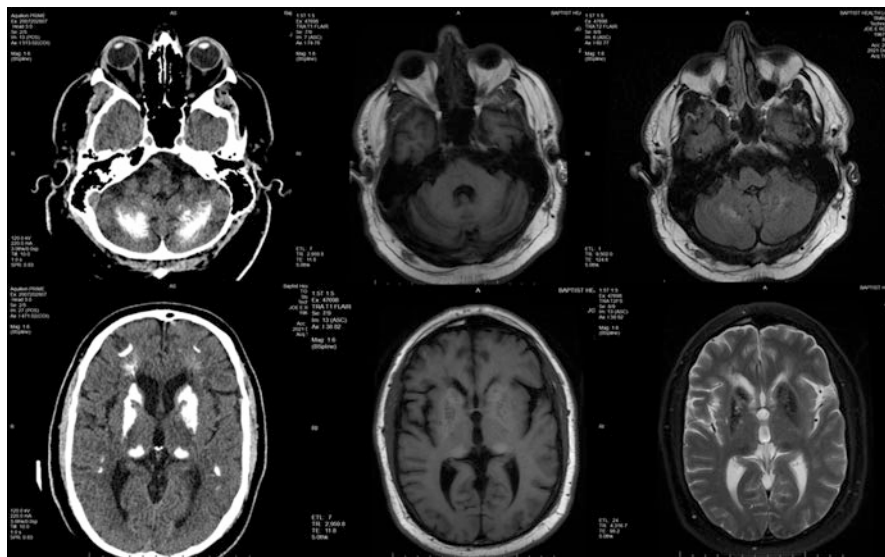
CT (left panels), T1-weighted and T2-weighted MRI (middle and right panels) of a patient with the iatrogenic primary hypoparathyroidism showing widespread calcifications in the basal ganglia and cerebellum
